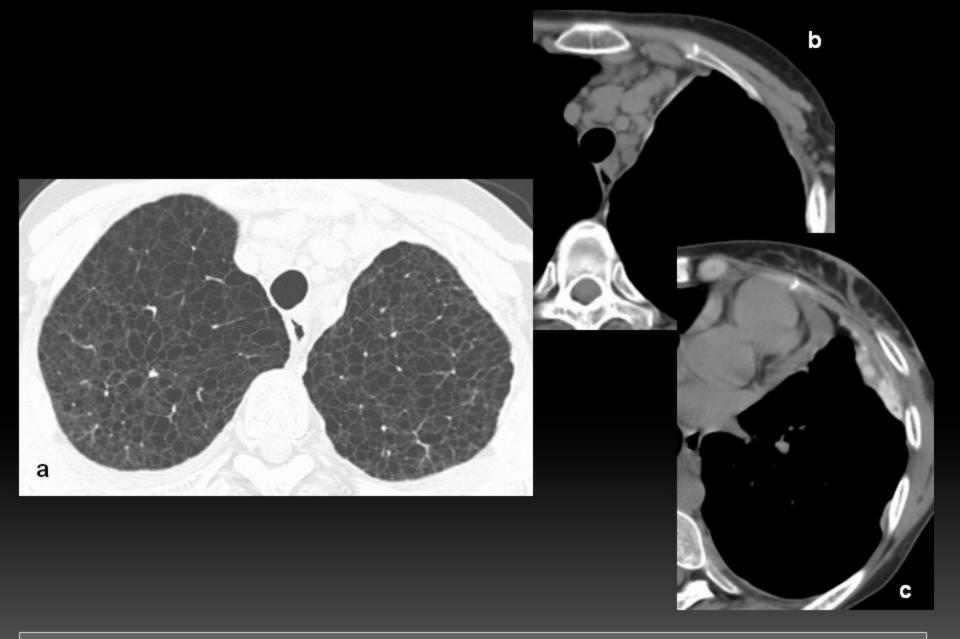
Woman, 31 years old with LAM and an episode of hemoptysis. Thoracic CT discloses uncountable lung cysts in both lungs with thin wall and round morphology(a), lymphadenopathy (b) and thickening of left pleura which have spontaneous high attenuation – talc (c).
